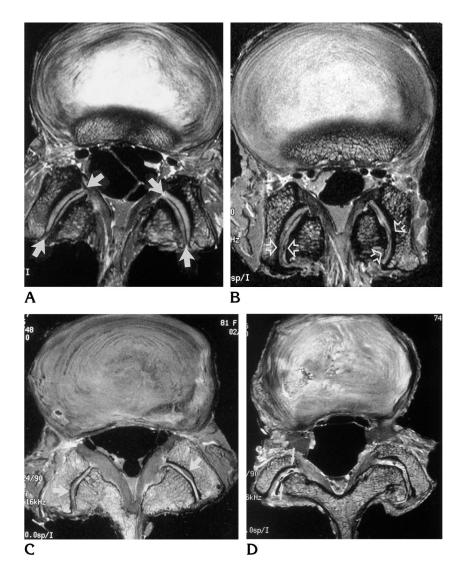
Four grades of facet joint degeneration on MRI. A. Grade 1: normal. B. Grade 2. Joint space narrowing or mild osteophyte. C. Grade 3: Sclerosis or moderate osteophyte. D. Grade 4: Market osteophyte. Note: Adapted from Grogan, J., Nowicki, B. H., Schmidt, T. A., & Haughton, V. M. (1997). Lumbar facet joint tropism does not accelerate degeneration of the facet joints. American Journal of Neuroradiology. 18(7), 1325-1329.
